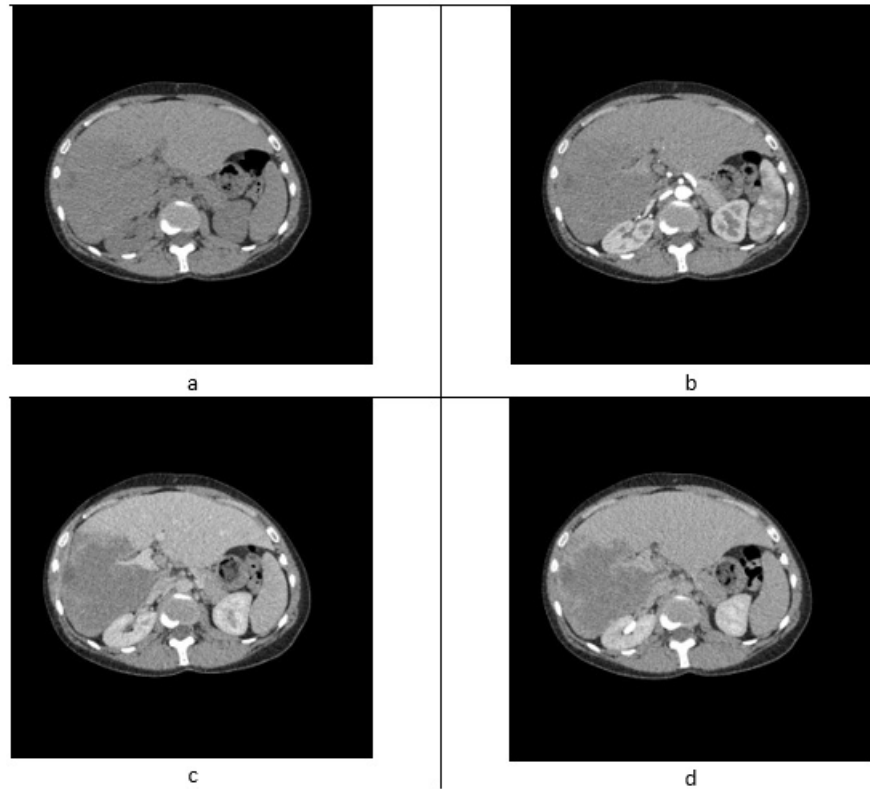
Axial multiphase CT scans obtained during the (a) precontrast, (b) arterial, (c) venous, and (d) delayed phases show an hypodense mass in the right liver lobe. The lesion shows hypoattenuation in the precontrast phase and no evidence of contrast enhancement after intravenous contrast injection.
